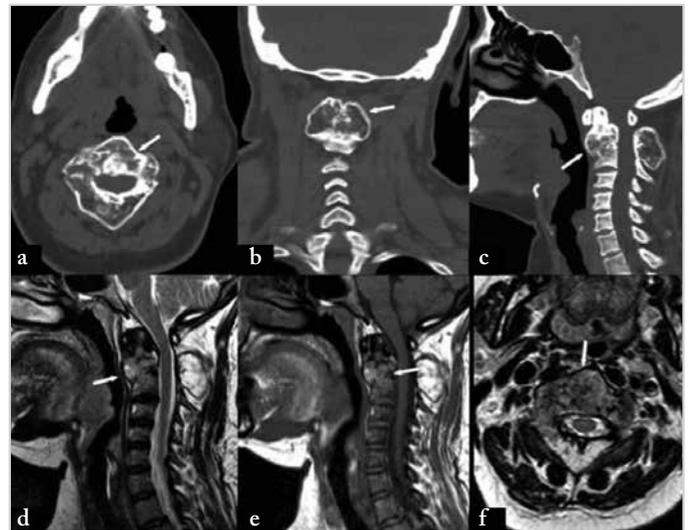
Axial (a), coronal (b) and sagittal (c) MDCT; sagittal T1- (d), T2- (e) and axial T2-weighted (f) MR images of a 50-year-old female patient showing the involvement of the vertebral body and posterior elements of the second cervical vertebra with an expanded and lytic lesion secondary to fibrous dysplasia. Extension of the C2 vertebral mass to hypopharynx caused dysphagia
